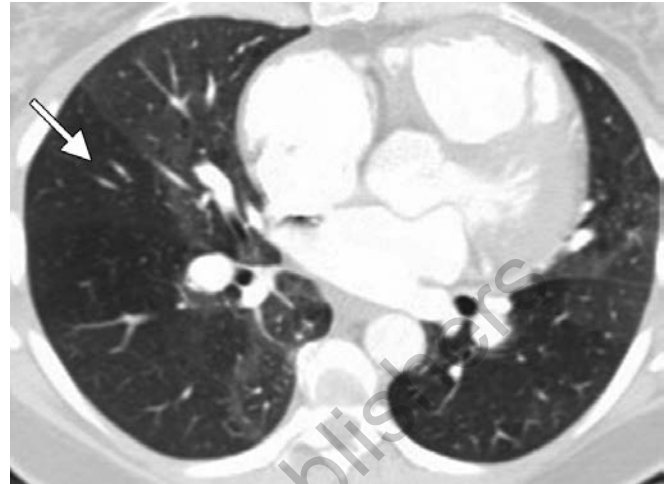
CT chest through the lower lobes demonstrating a pattern of variable regional areas of decreased and increased attenuation, also known as mosaic attenuation. This patient had chronic thromboembolism. Note the decreased vascularity in the hypolucent areas of the lung (arrow)
